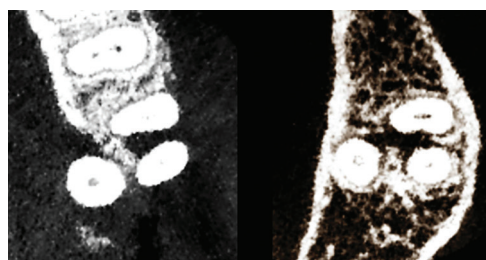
Example CBCT cross-sectional images in the axial plane of (left) sample no. 1's defect showing remaining bone covering the palatal root surface within the lesion and (right) sample no. 4's defect showing no remaining bone.
